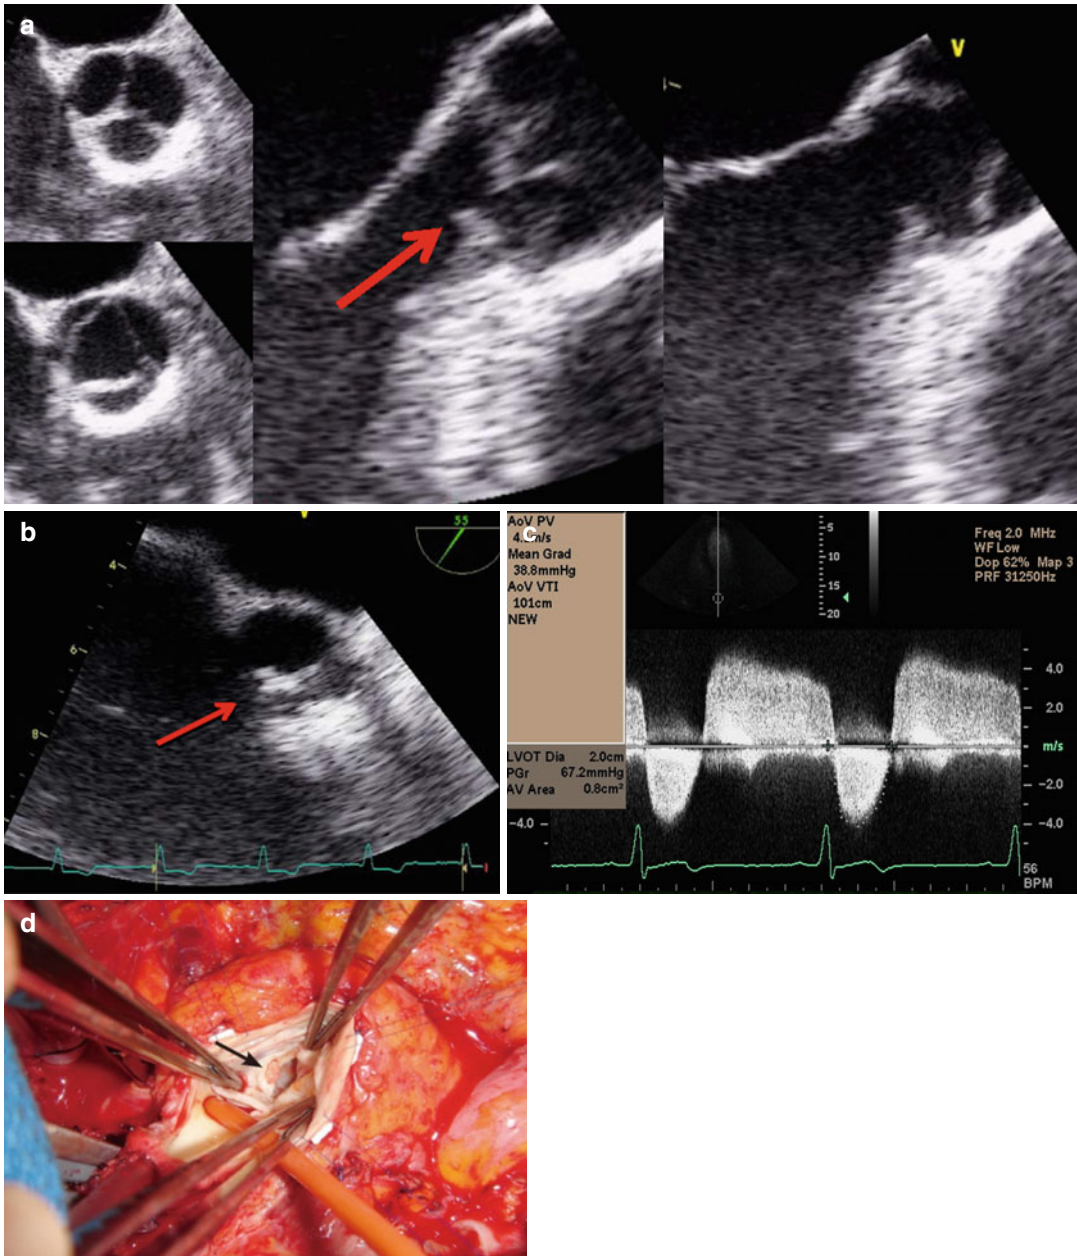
Subaortic membrane: on TEE (*top left, a*) long axis, short axis (*top right, b*). Doppler across the LVOT revealing aortic stenosis and regurgitation (*bottom left, c*).
